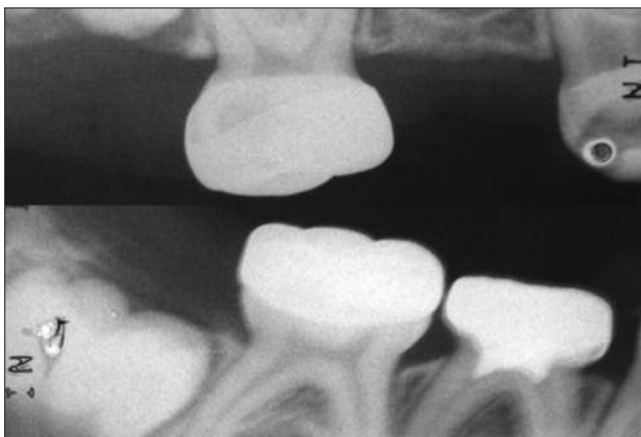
Bitewing radiograph of the right side
